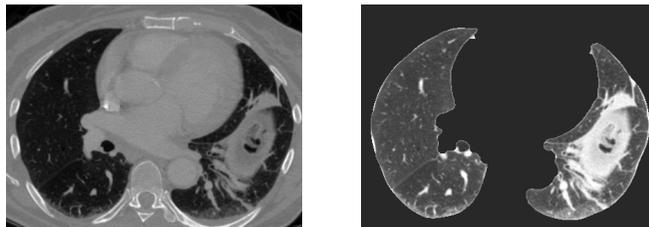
Original image slice [Left] and final masked lung volume [Right] shown at a lower-thoracic axial CT slice location (slice #204 out of 525) in LIDC study #0034. The segmentation outcomes at each major step for this dataset at this slice location are depicted in Figure 2. A large abdominal tumorous mass is seen protruding into the left hemi-lung (right side of image). Airspace of the bowels is seen as voids within the center of the protruding mass.
